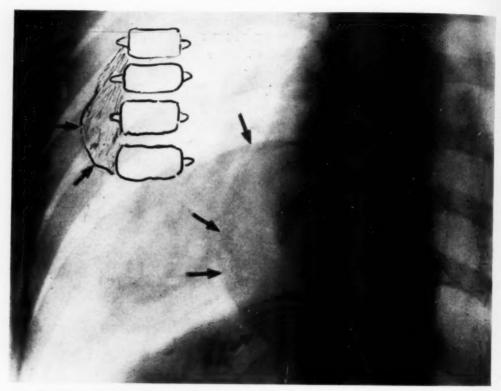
Extra-osseous hydatidosis. Hydatid abscess with softening of the bone (ossifluent abscess). There are no radiographic signs permitting differentiation from a tuberculous abscess, but the vertebral lesion is characteristic of hydatidosis.
